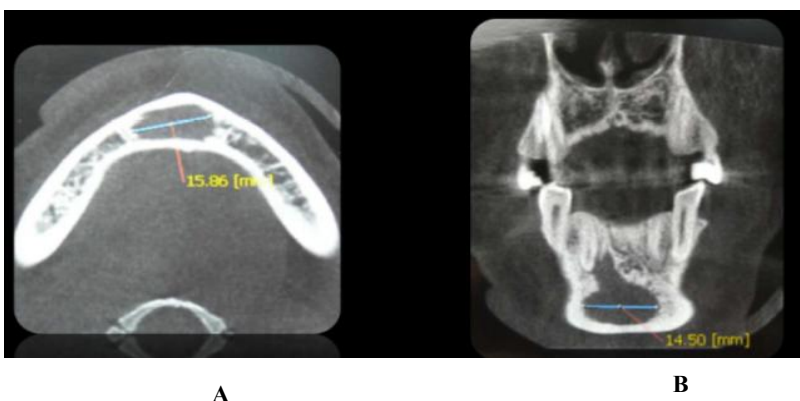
CBCT images of lesion. year 2013
